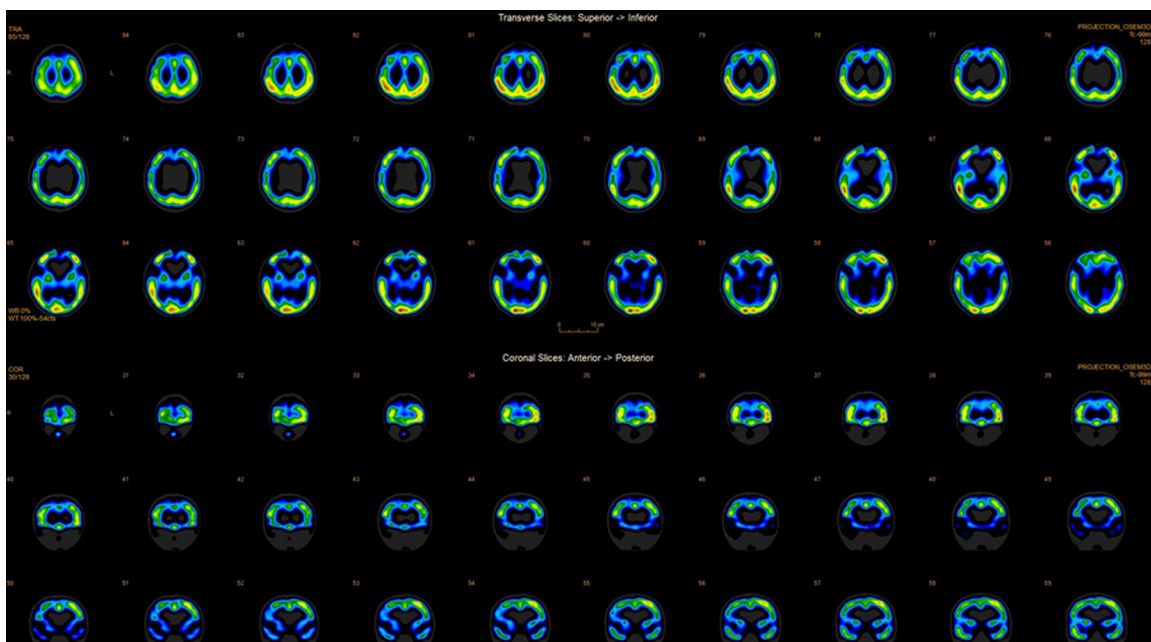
SPECT showing bilateral hypoperfusion in frontal lobes.
